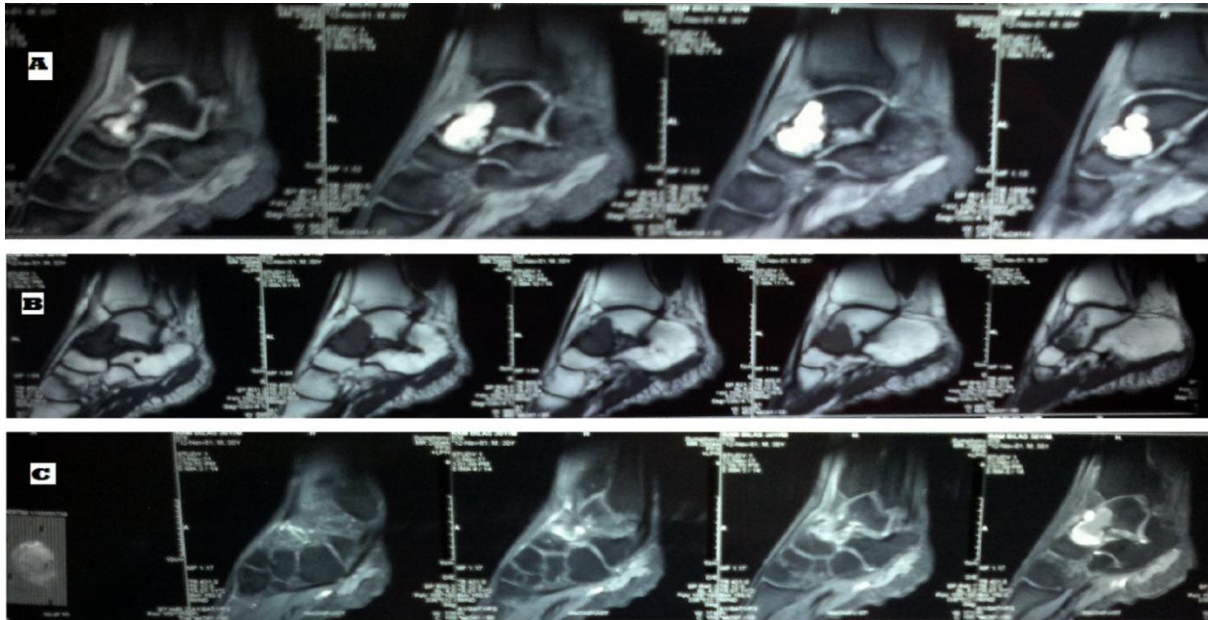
MRI of foot and ankle with lesion in head, neck and anterior part of body of talus. A) Hyper intense on T1W image B) Hypo intense on T2W image and C) Contrast enhanced MRI showing heterogeneous enhancement of the lesion.
